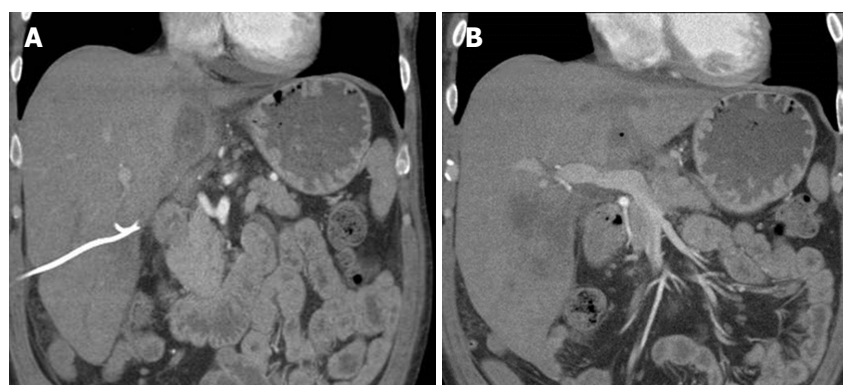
Abdominal computed tomography images showing the superficial, inferior lobe to be well drained with the pigtail in place (A), but the deeper superior collection containing a small bubble of gas (B).
